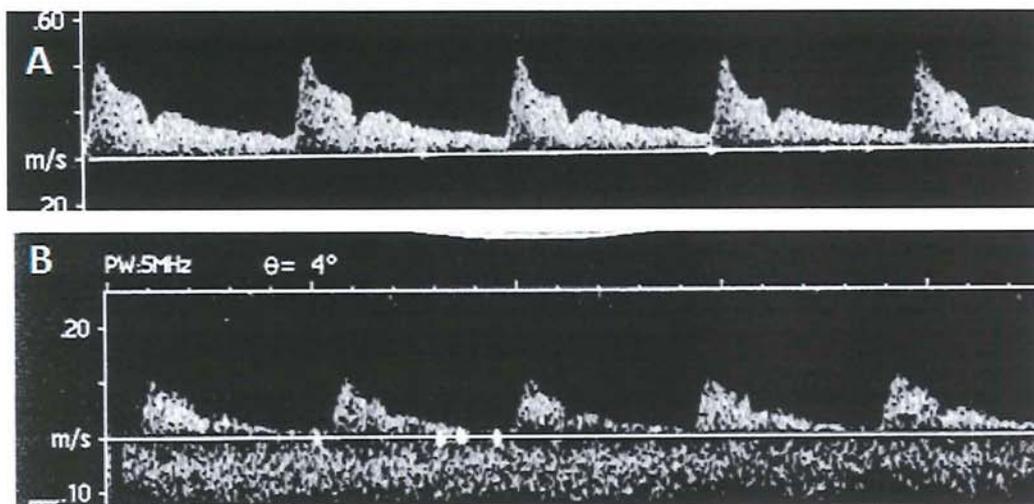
Graphical representation of the spectral wavelines as recorded using Colour Doppler Imaging (A) Spectral wave shape of the ophthalmic artery; (B) Spectral wave shape of the central retinal artery
